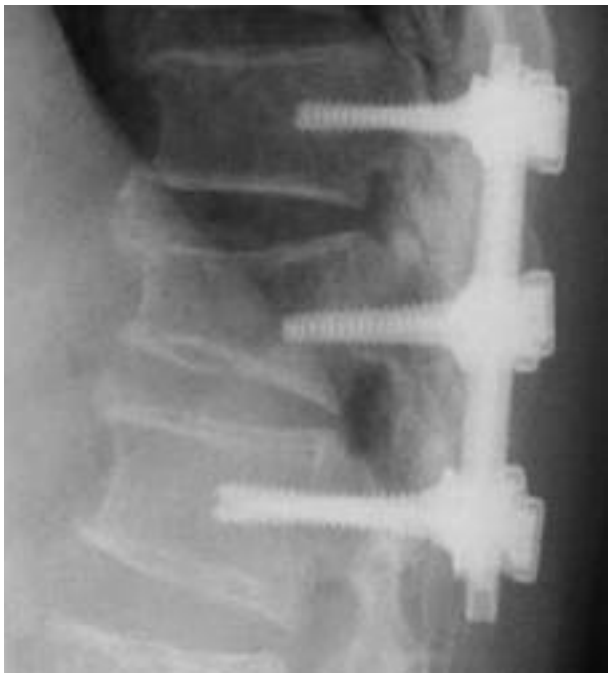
The postoperative plain lateral radiograph shows that ossified mass was removed.
